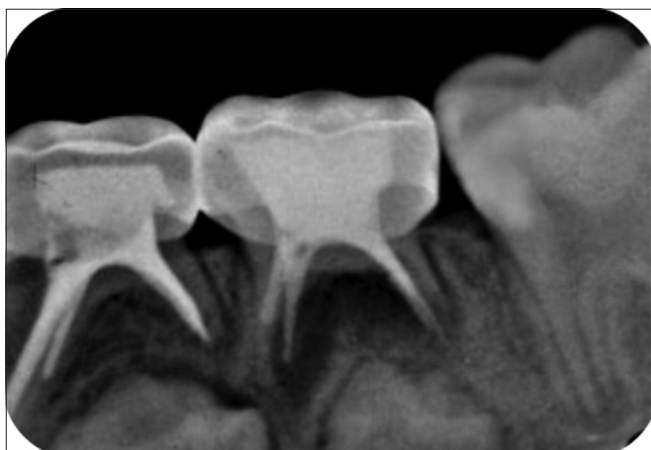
Periapical radiograph at the 2<sup>nd</sup> follow-up (6 months)
